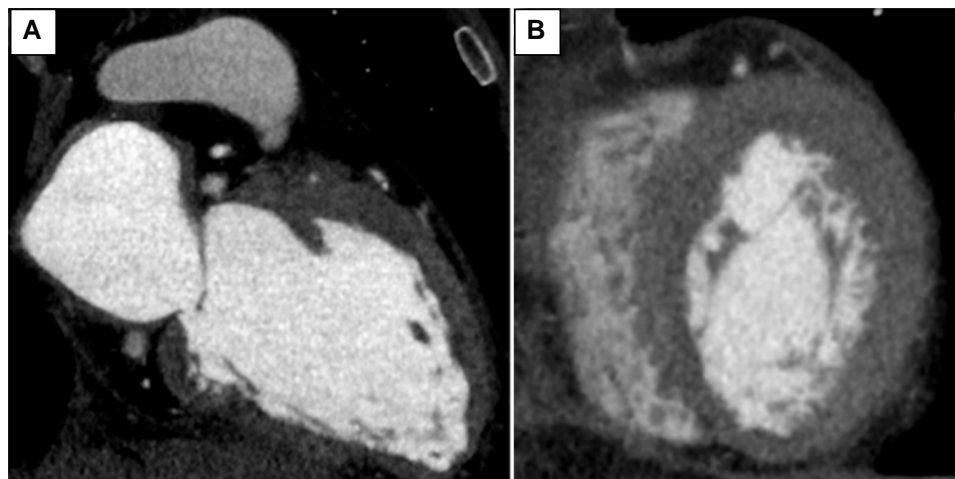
Postoperative computed tomography: the thrombi have been completely removed. (A) Long-axis view. (B) Short-axis view.
